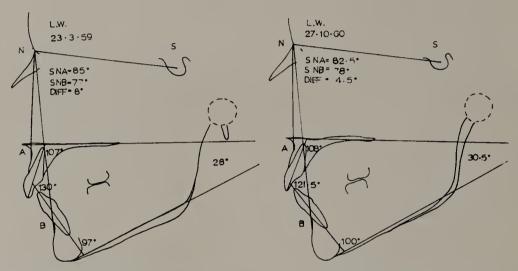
Tracings from lateral X-rays of case shown in Fig. 5. These show dento-alveolar re-orientation following extra-oral traction to maxillary arch.
